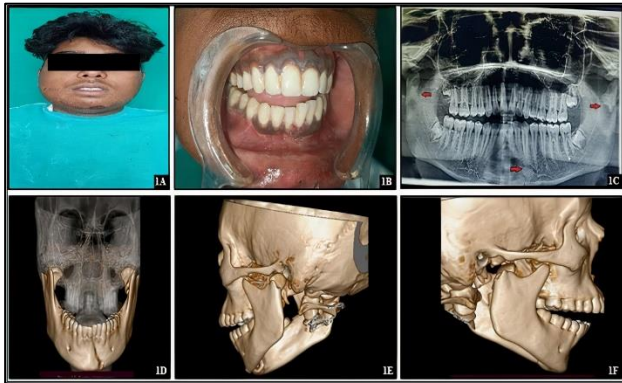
(A and B) Pre operative extraoral and intraoral view of patient. (C) Preoperative OPG revealing fracture of left parasymphysis and left and right condylar process of mandible (red arrows). (D) Preoperative frontal view of CT scan showing left parasymphyseal fracture. E, F) Preoperative lateral view of CT scan exhibiting left and right displaced fracture of condylar process.
